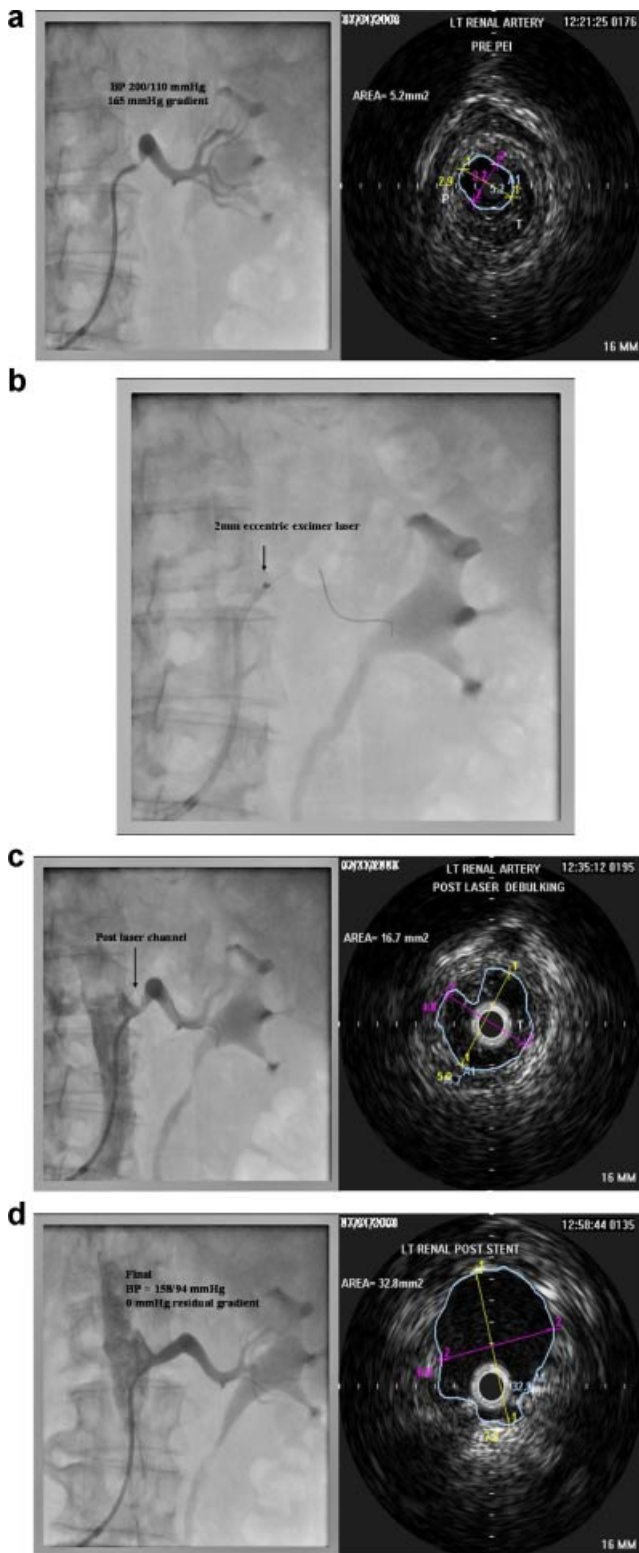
Excimer laser angioplasty in a patient with uncontrolled HTN and angina. Left renal artery eccentric, 95% ostial–proximal stenosis is present. a: Pre-intervention angiogram and corresponding renal ultrasound (P denotes plaque, T denotes plaque/possible thrombus). b: Debulking of the ostial stenosis with a 2-mm eccentric laser catheter. c: Post-laser recanalization with corresponding ultrasound (T denotes residual thrombus). d: Final angiographic result with corresponding ultrasound.
